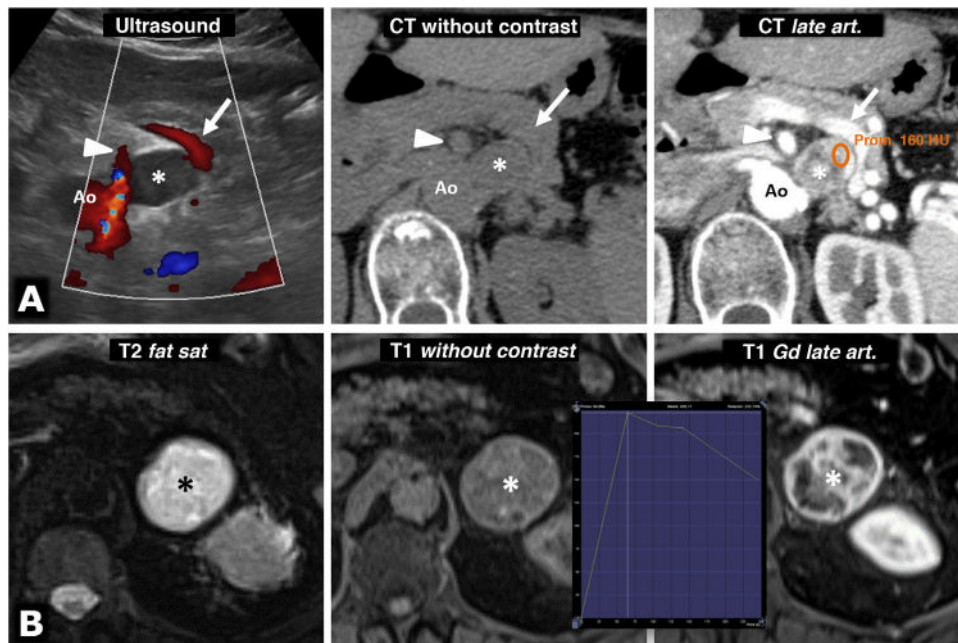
Intense enhancement in pheochromocytomas. A) 74-year-old female. Incidental ultrasound finding of a well-defined, slightly heterogeneous solid hypoechoic nodule (*), located between the splenic vein (arrows), the superior mesenteric artery (arrowheads) and the aorta (Ao). The CT shows intense and heterogeneous enhancement in the late arterial phase, in which it reaches 160 HU in some areas, with moderate washout in later phases (not shown). B) 73-year-old male. During investigations for grade II hypertension, a left adrenal mass was found (*), which on MRI behaves with high signal intensity on T2-weighted images, with marked enhancement (relatively greater than 220%), with a peak in the late arterial phase of the dynamic study. The hypertension was corrected after laparoscopic adrenalectomy.
